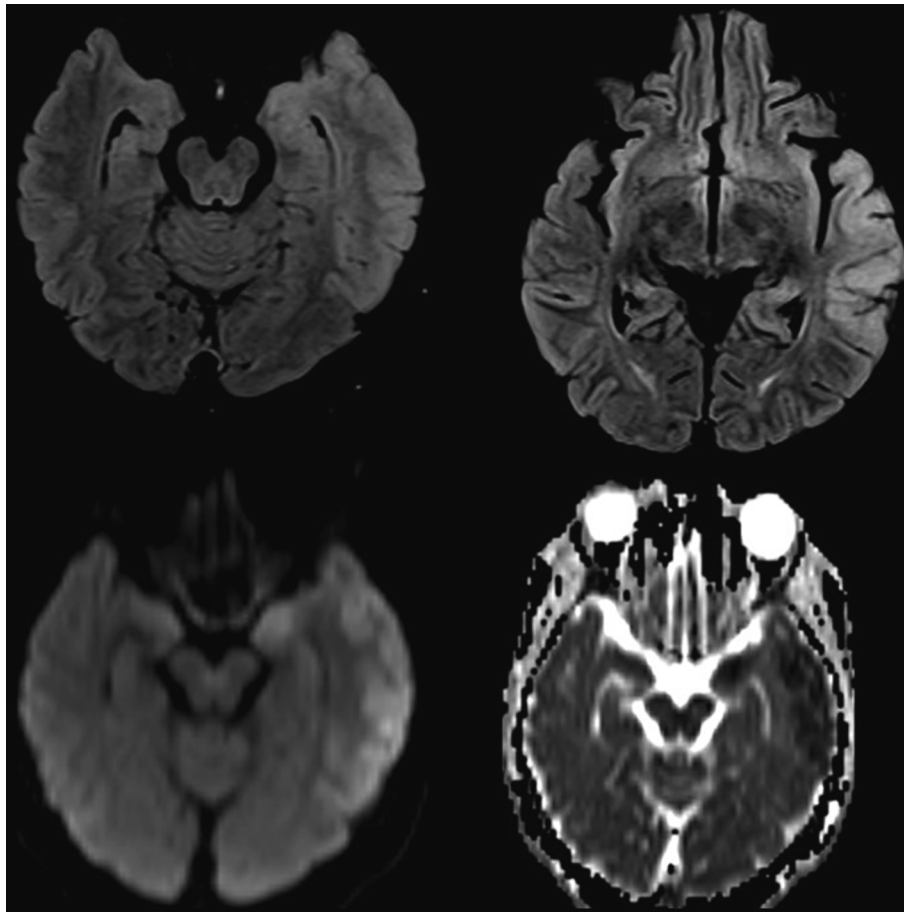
MRI brain T2/FLAIR hyperintensities with restricted diffusion predominantly involving cortical grey matter of left parahippocampal gyrus, amygdala, lateral temporal lobe, parieto-temporal junction in a gyriform pattern on left side and deep grey matter of left pulvinar nucleus. (Case 28).
